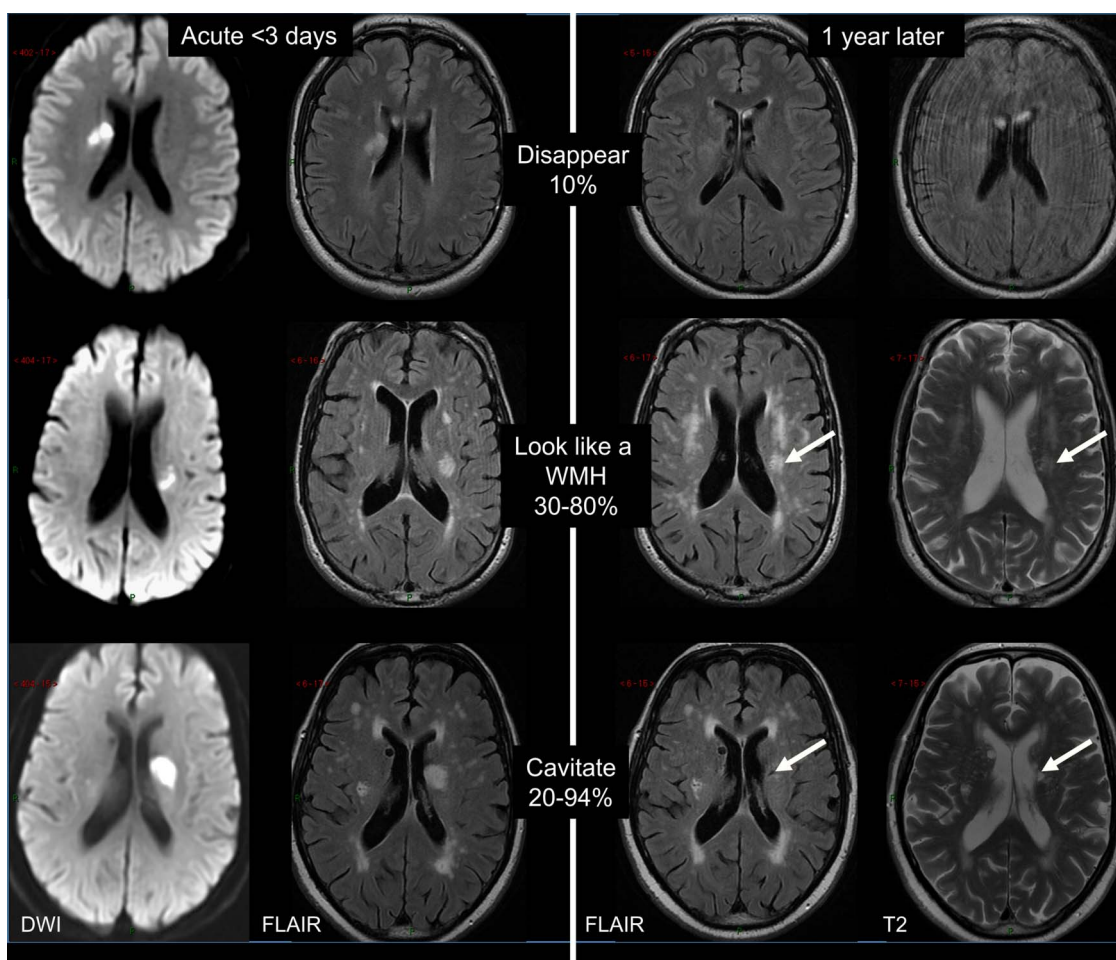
Long-term appearances of lacunar infarcts (arrows: old stroke lesion on the follow-up scans). DWI, diffusion-weighted imaging; FLAIR, fluid-attenuated inversion recovery; WMH, white matter hyperintensity.
